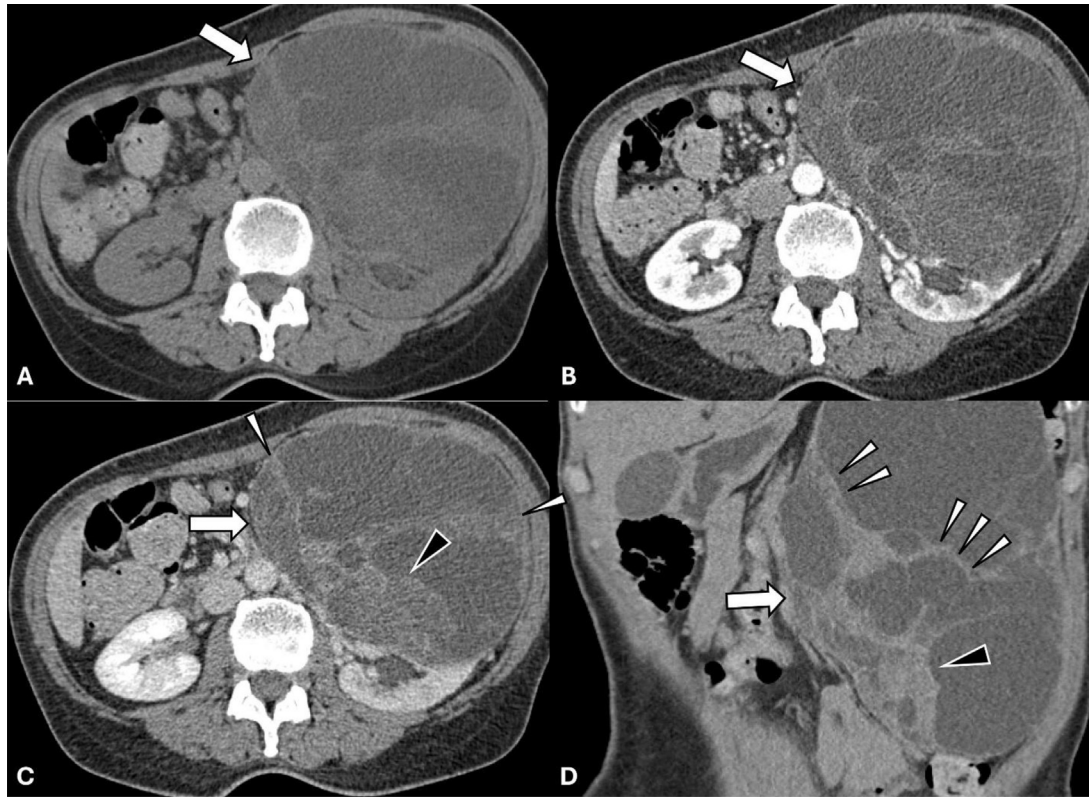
61-year-old with flank pain. Axial unenhanced (A), axial corticomedullary phase contrast-enhanced (B), nephrographic phase contrast-enhanced (C), and coronal (D) excretory phase contrast-enhanced CT demonstrate a large left renal cystic mass (arrows) centered about the anterior interpolateral cortex, with multiple thickened septa (white arrowheads) with possible nodular component (black arrowheads).
